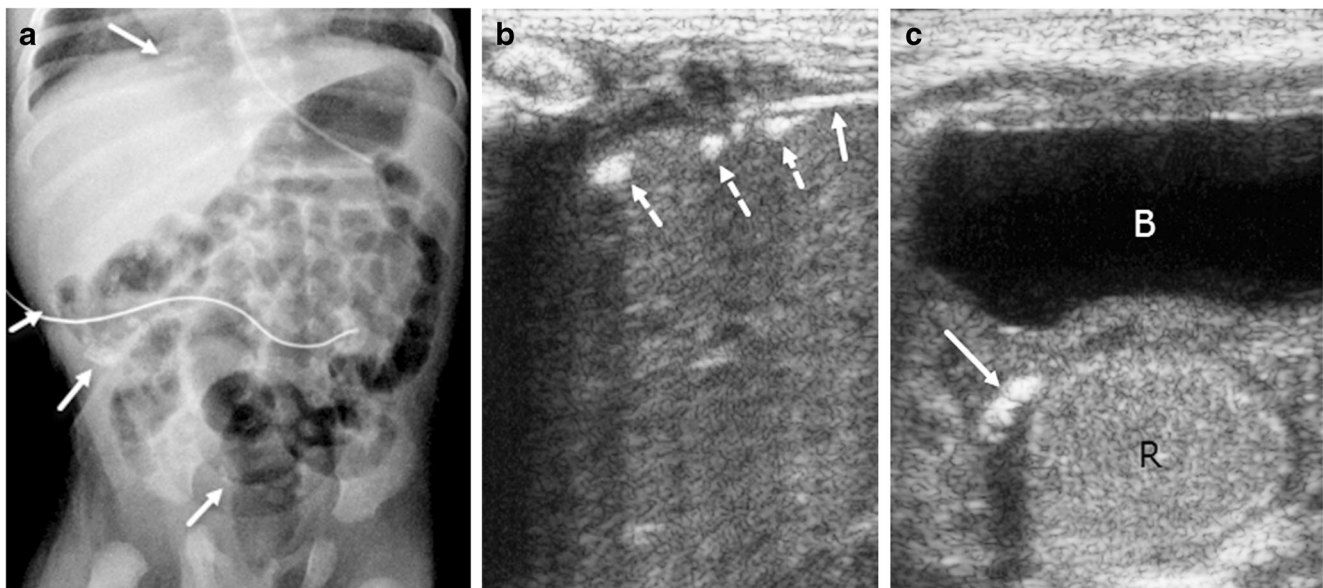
Diffuse peritoneal calcification in a preterm boy born with fetal diagnosis of meconium peritonitis (gestational age 32 weeks). a Anteroposterior portable supine radiograph of the abdomen obtained the first day of age shows calcifications (*arrows*) in the right upper quadrant, right flank and pelvis. b Transverse ultrasound image obtained with a linear probe of the liver done the same day
